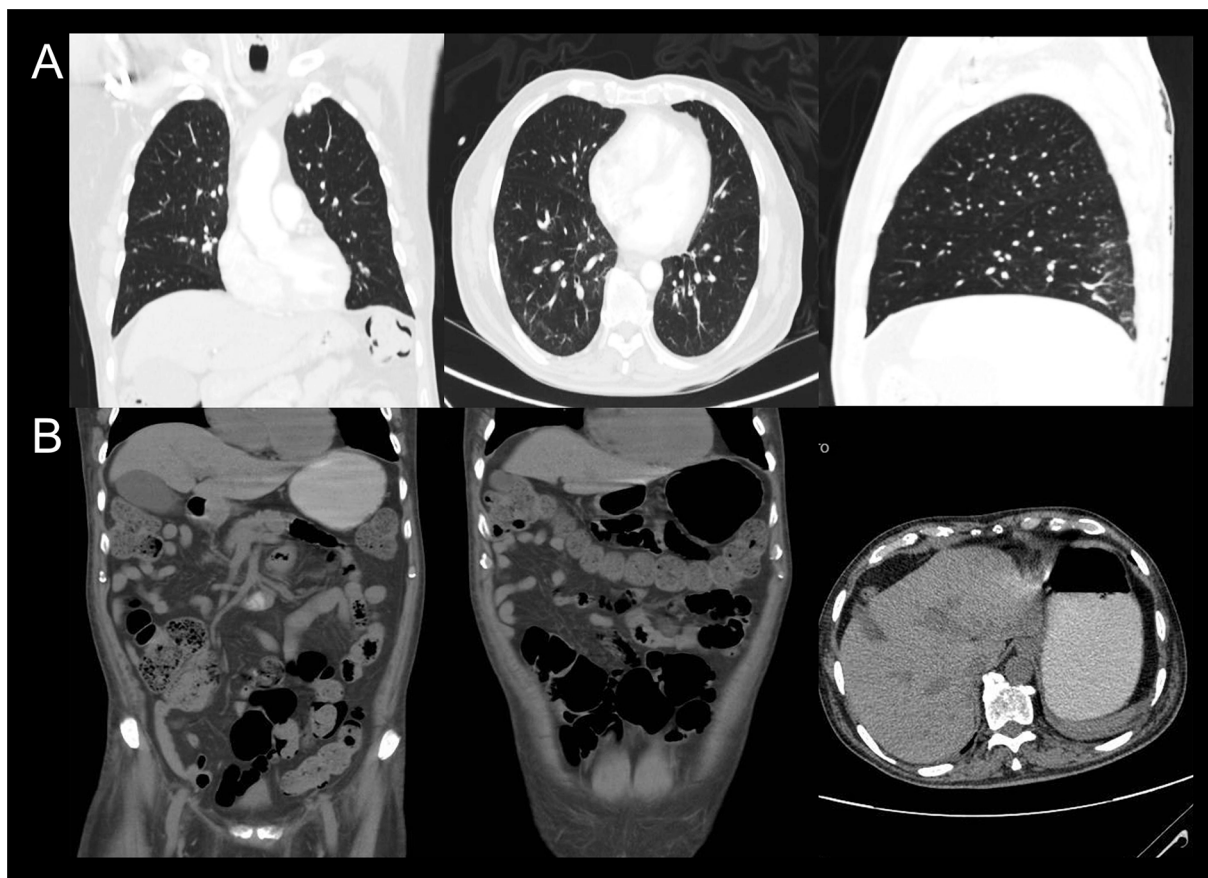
Thoracoabdominal CT scan demonstrating no signs of COVID-19 pneumonia. (A) Coronal (left), transverse (middle), and sagittal (right) CT scan images of the lung that demonstrate typical characteristics of the organ. (B) Coronal (left) and transverse (right) CT scan images of the abdomen that show distention of the stomach, small intestine, colon, and even gallbladder, associated with the retention of stool due to the autonomic dysfunction of the patient.
